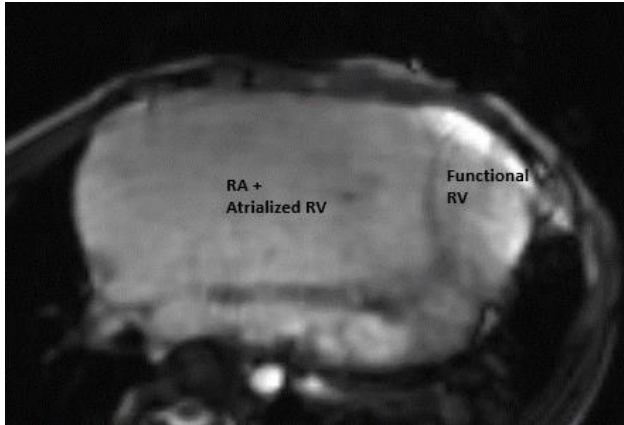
Cardiac MRI 4 chamber view showing small functional RV.
